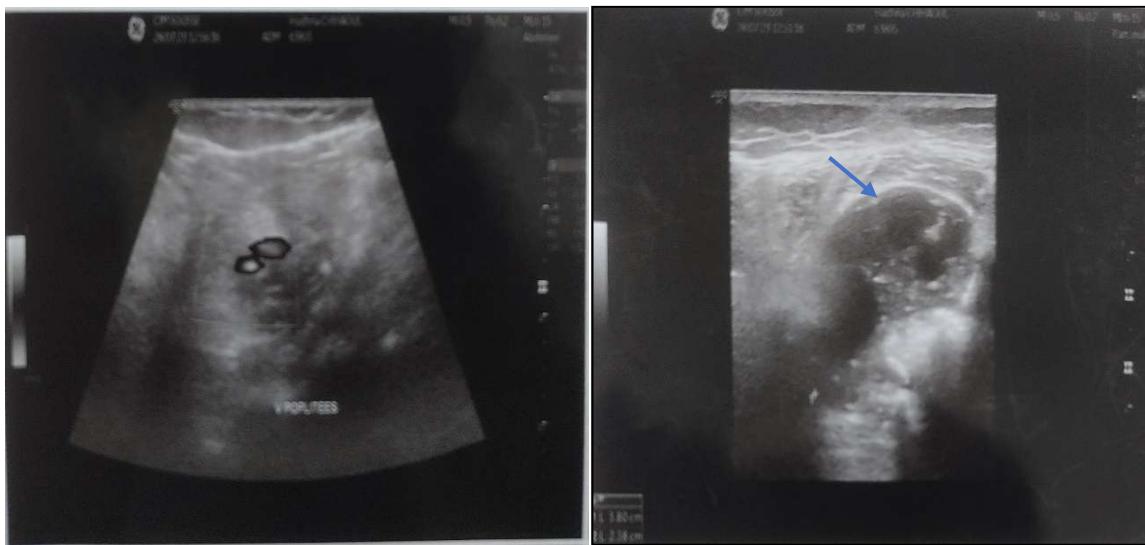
Ultrasound showing heterogeneous echostructure consisting of multiple cysts with anechoic content
